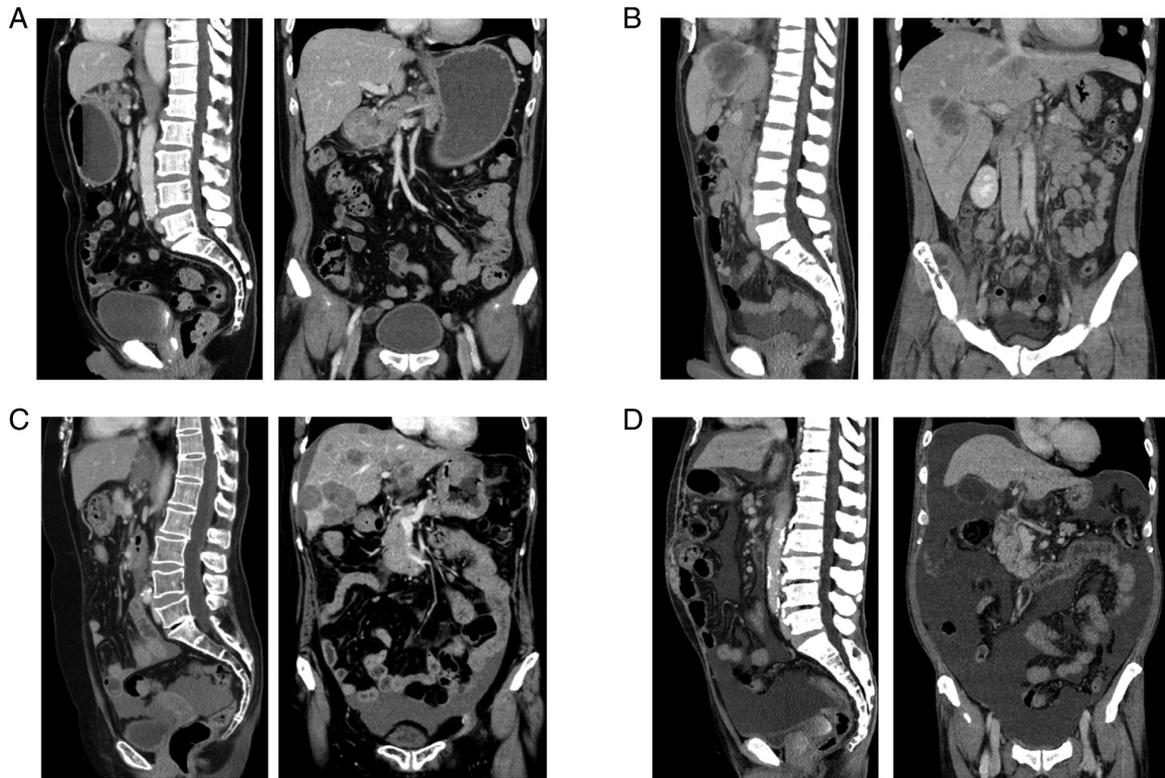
The staging of ascites. (A) The representative images of CT show no ascites. (B) The representative images of CT show small ascites (within the pelvic cavity). (C) The representative images of CT show moderate ascites (beyond the pelvic cavity). (D) The representative images of CT show massive ascites (extending throughout the abdominal cavity). CT, computed tomography.
